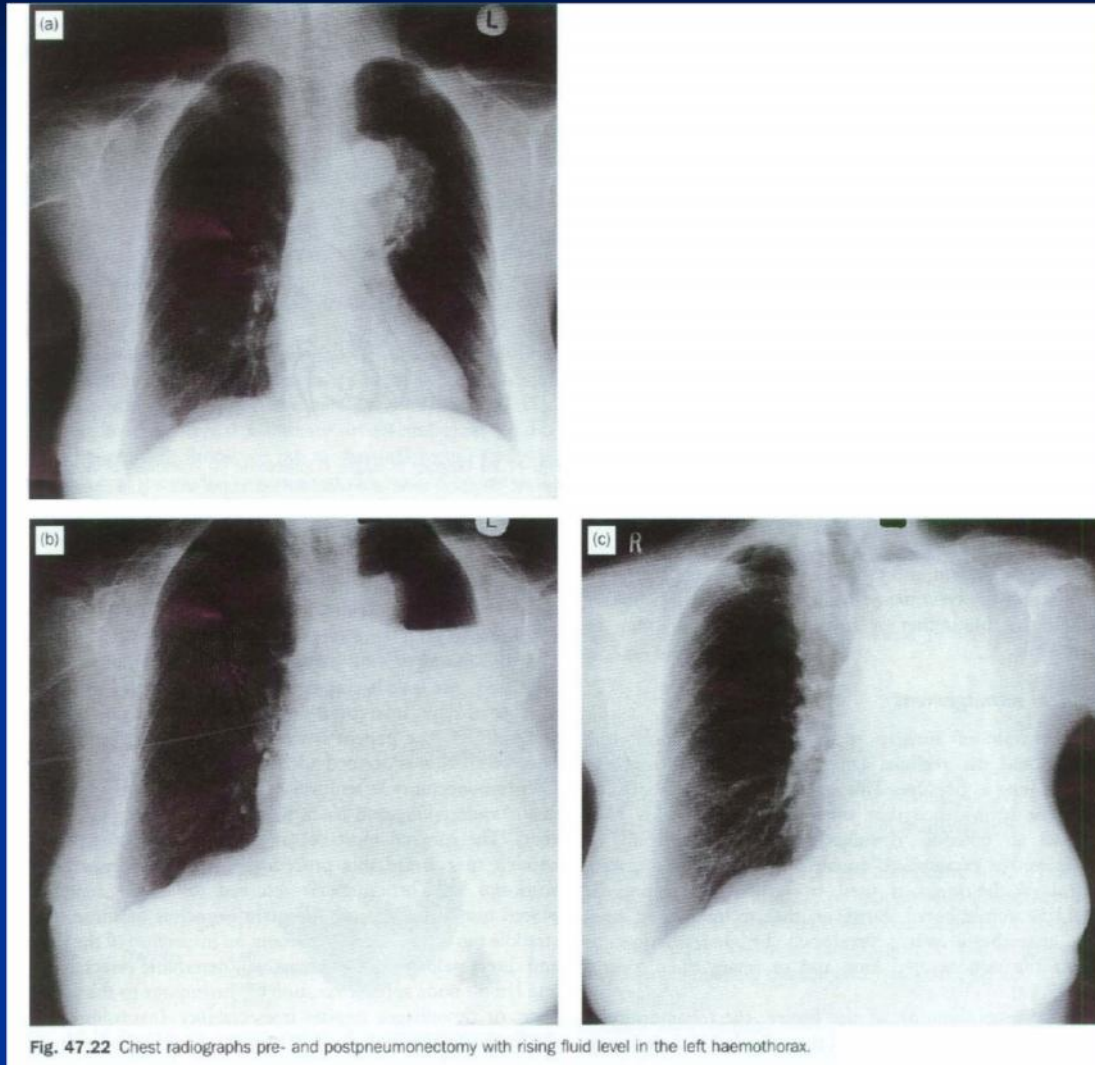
Chest radiographs pre- and postpneumonectomy with rising fluid level in the left haemothorax.
